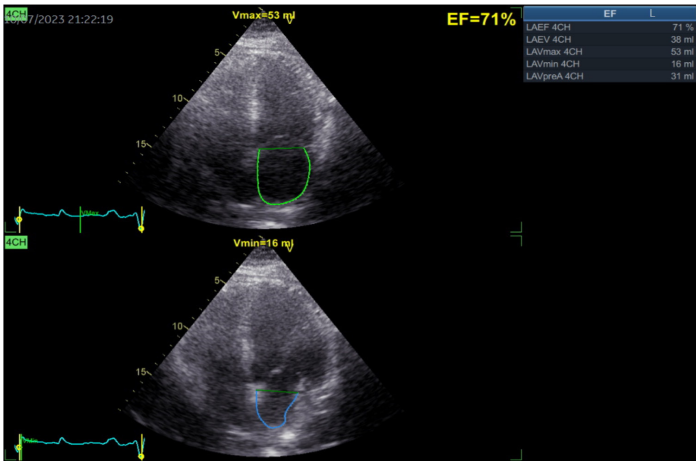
Apical 4 chamber view calculating left atrium maximum and minimum volumes and emptying fraction
